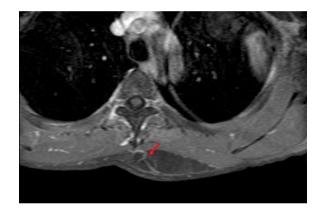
In-flowing blood vessels. Axial contrast-enhanced T1-weighted MRI shows a lipoma of the upper back. The linear enhanced lesions (red arrow) indicate blood vessels that flow into the tumor
